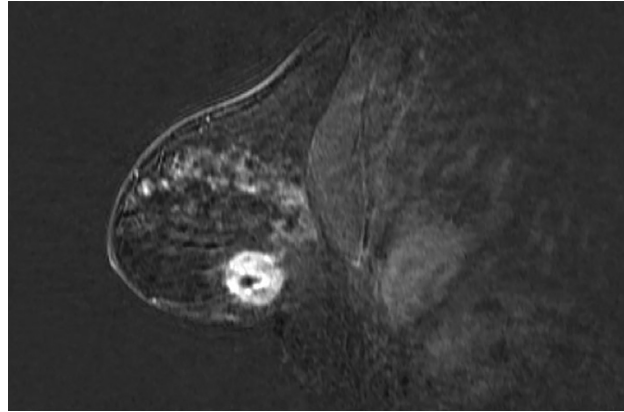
Details of the patient's magnetic resonance imaging findings preoperatively.
